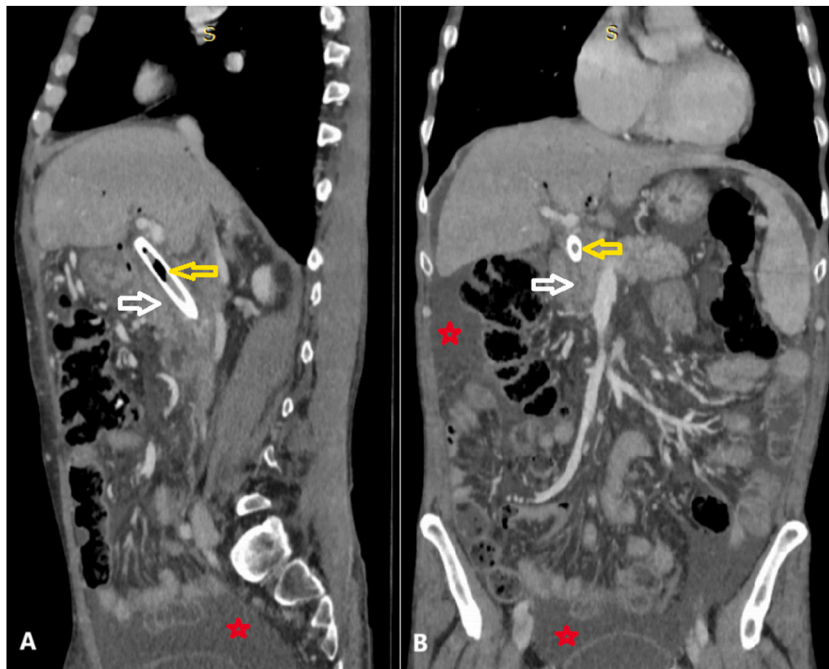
Multiplanar reconstructed CT images demonstrating a thickened wall of the common bile duct consistent with cholangiocarcinoma (white arrow), the presence of a biliary stent (yellow arrow) with associated aerobilia, and ascites (red star).
